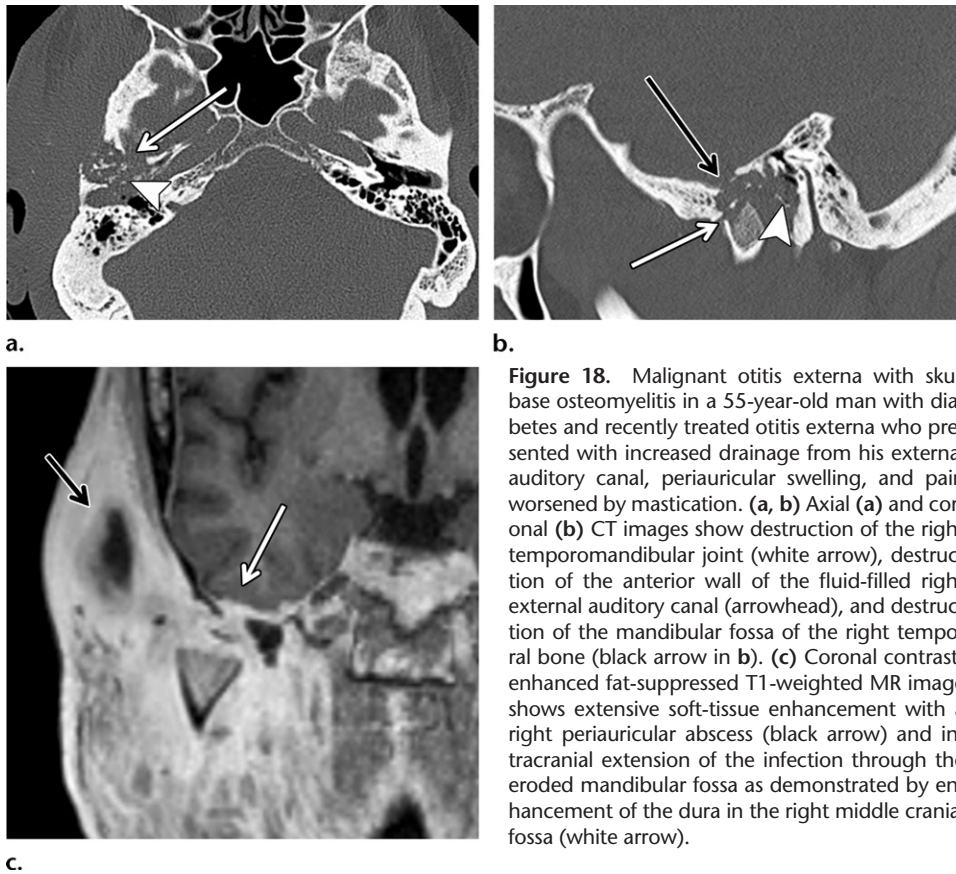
Malignant otitis externa with skull base osteomyelitis in a 55-year-old man with diabetes and recently treated otitis externa who presented with increased drainage from his external auditory canal, periauricular swelling, and pain worsened by mastication. (a, b) Axial (a) and coronal (b) CT images show destruction of the right temporomandibular joint (white arrow), destruction of the anterior wall of the fluid-filled right external auditory canal (arrowhead), and destruction of the mandibular fossa of the right temporal bone (black arrow in b). (c) Coronal contrast-enhanced fat-suppressed T1-weighted MR image shows extensive soft-tissue enhancement with a right periauricular abscess (black arrow) and intracranial extension of the infection through the eroded mandibular fossa as demonstrated by enhancement of the dura in the right middle cranial fossa (white arrow).
